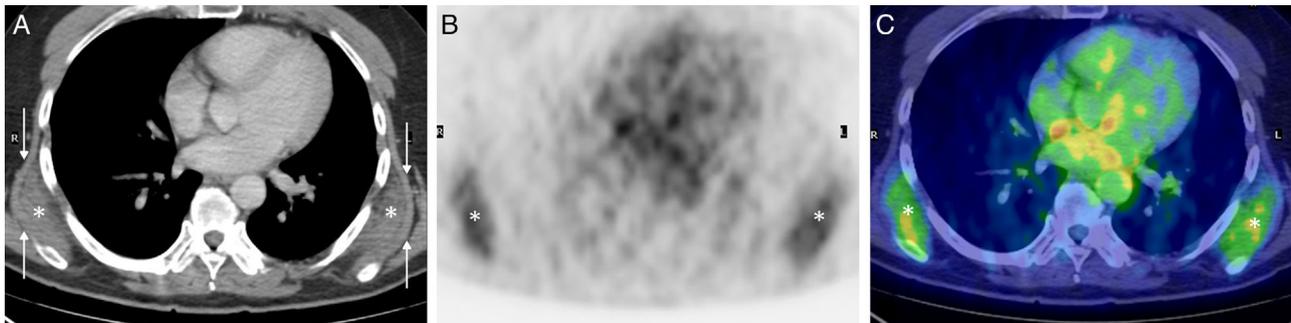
(A) Axial image of the CT component of the PET/CT study showing masses (asterisks) between the tip of each scapula and the chest wall. Note the latissimus dorsi muscle (arrows) covering each mass. (B and C) Axial images from the PET component (B) and the PET/CT fusion (C) showing subscapular hypermetabolic masses (asterisks).
